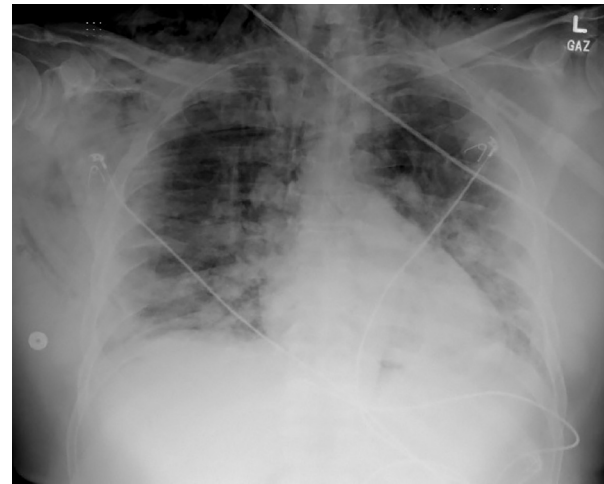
Chest X-ray after desaturation noting a likely pneumomediastinum and bilateral diffuse airspace disease.
